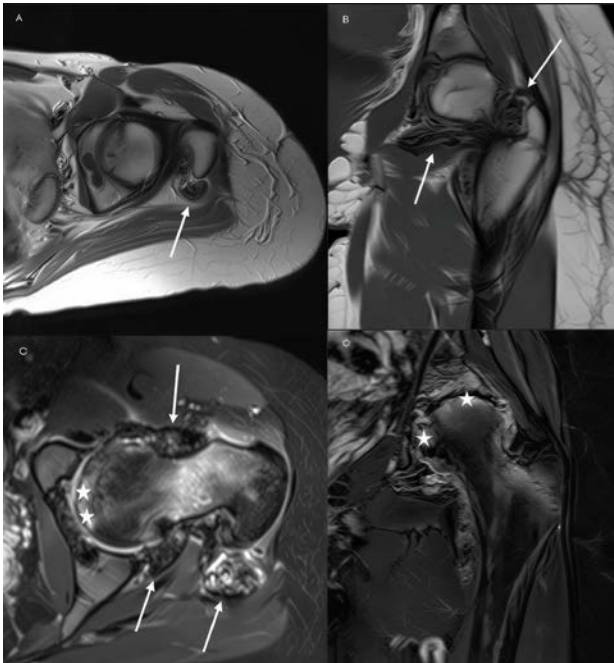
MRI of the hip demonstrates diffuse intra-articular TSGCT with extensive synovial proliferation and solid components (arrows, A-C). The lesion shows diffuse synovial thickening with low-to-intermediate signal intensity on T1-WI (A, B) and heterogeneous enhancement of the solid components and the synovium on T1-WI after gadolinium administration (arrows, C and D). Adjacent osseous erosions and surrounding bone marrow (stars, C-D), reflecting the locally aggressive and infiltrative behaviour of diffuse intra-articular TSGCT.
